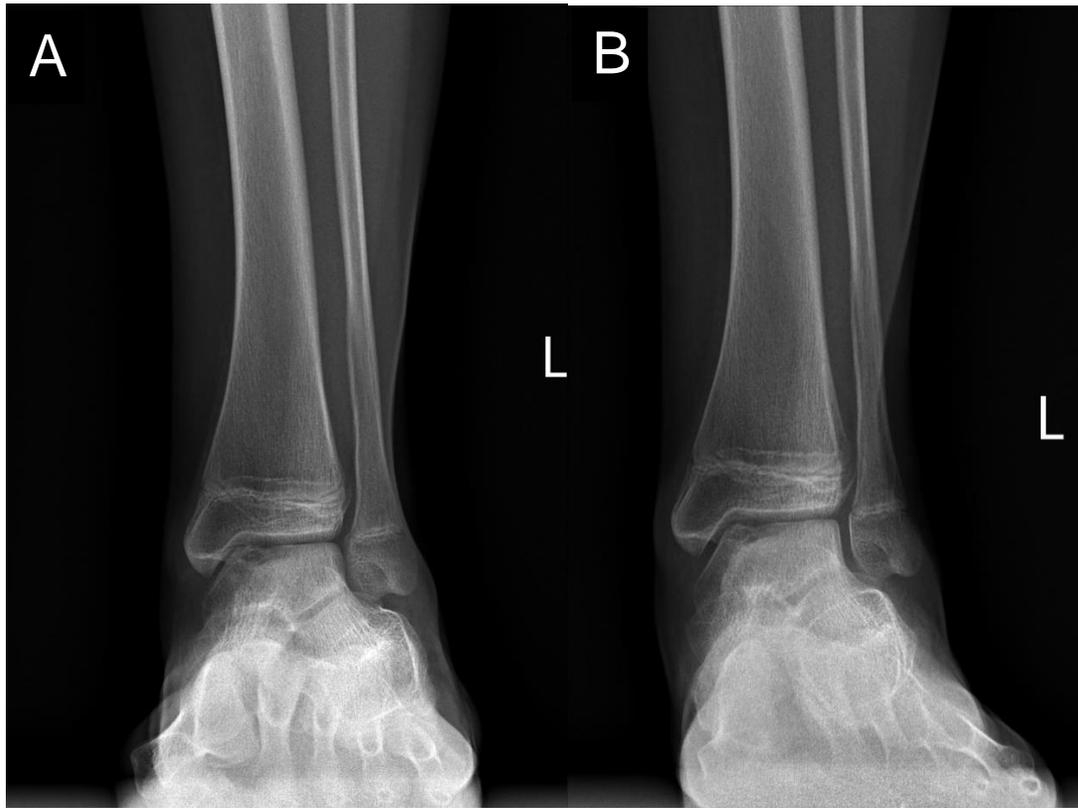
Pre-operative A) AP and B) mortise plain radiographs of a large medial talar dome osteochondral lesion/defect.
